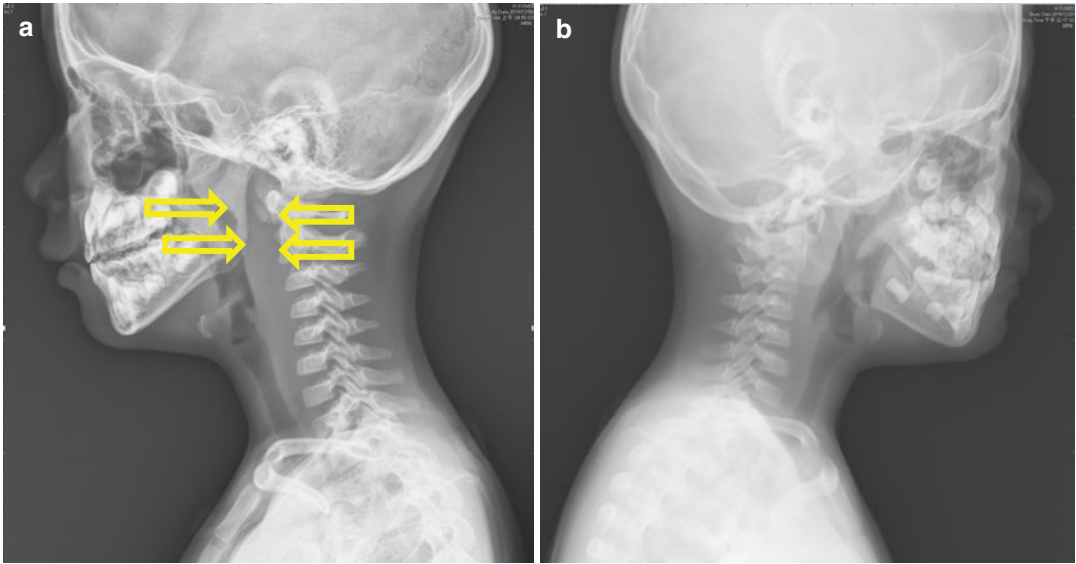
C-spine plain films showed widening of pre-vertebral space (approximately 1.5 times to the length of the vertebral body, arrows) from C2 to C5 on admission (a) and no more widening of prevertebral space after treatment (b)
